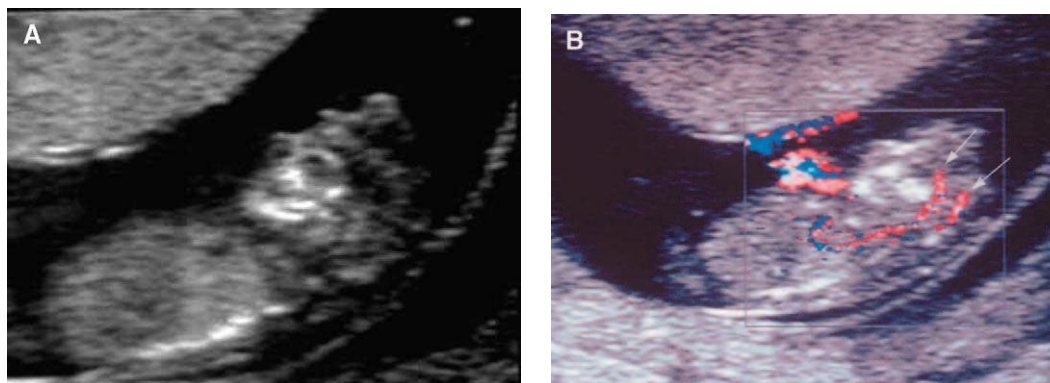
Anencephaly. Sagittal Gray-scale (A) and color Doppler (B) views show lack of an ossified cranium above the orbits. The internal carotid arteries are seen to extend to the skull base and then abruptly terminate (arrows). (Courtesy of Dr. Peter Callen, San Francisco, CA).
